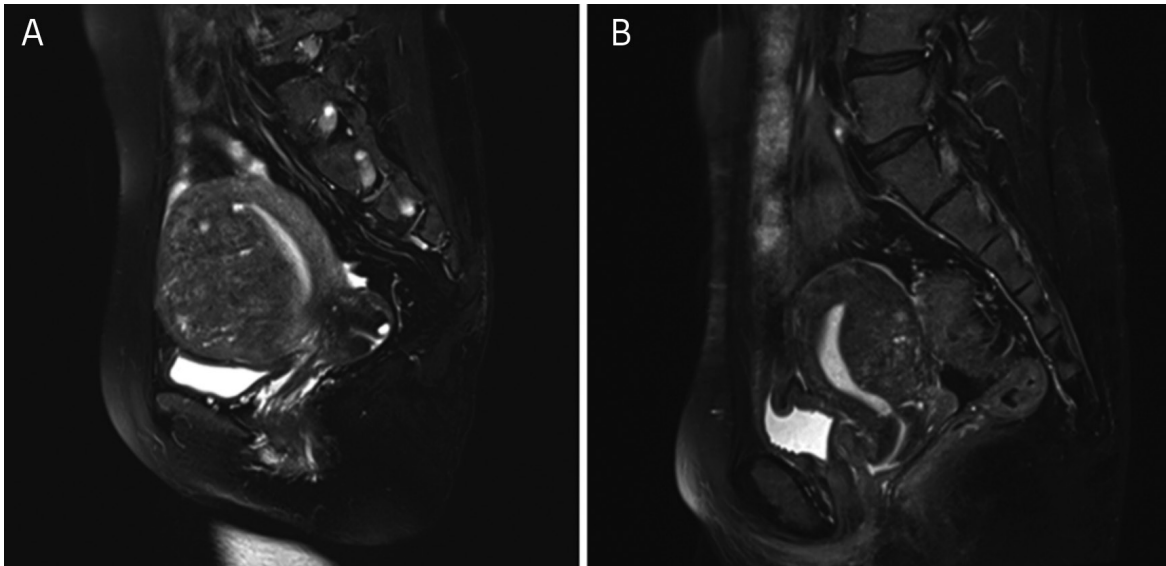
Magnetic resonance imaging of adenomyosis
